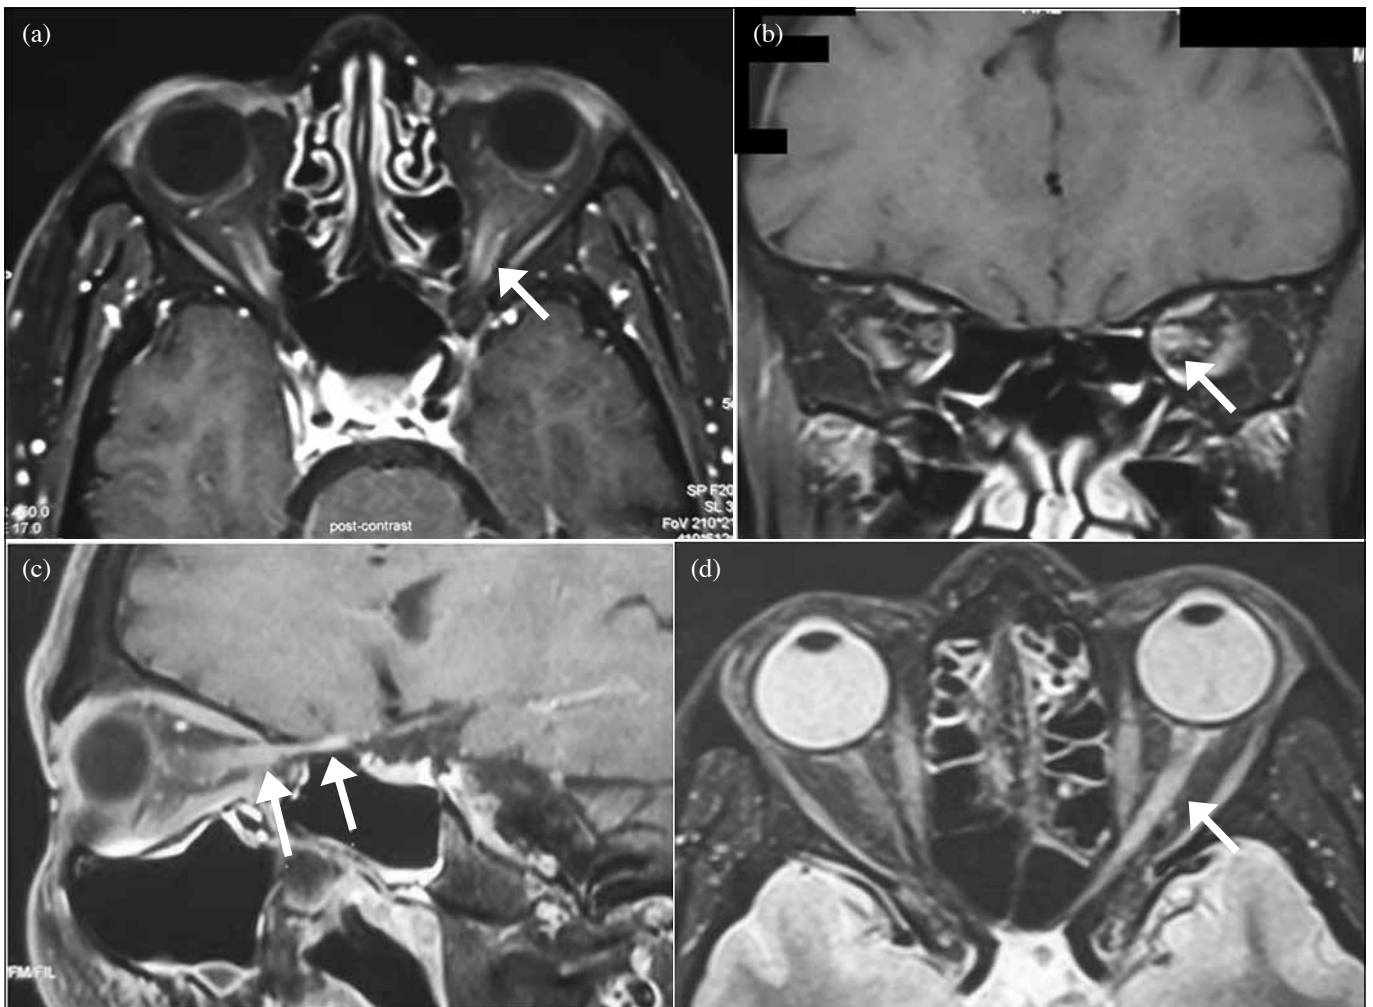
(a) T1-weighted fat-suppressed axial image showing tram-track enhancement of the left optic nerve sheath. (b) T1-weighted fat-suppressed coronal image showing ring-shaped enhancement of the left optic nerve sheath. (c) T1-weighted sagittal image showing intra-orbital and intra-canalicular optic nerve sheath enhancement. (d) T2-weighted axial image showing left optic nerve sheath enhancement.
